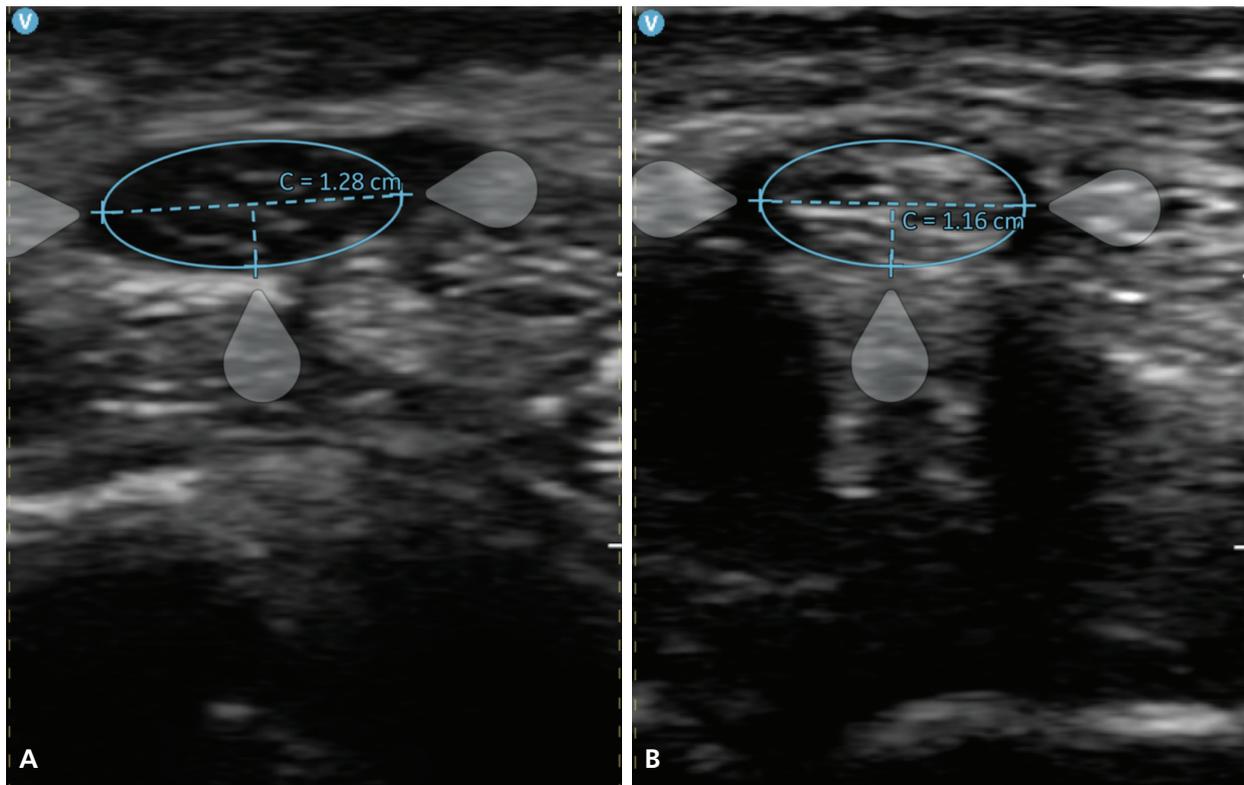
Ultrasound imaging at the carpal tunnel of the right median nerve (A) and the left median nerve (B). Circumference of the right median nerve: 1.28 cm. Circumference of the left median nerve: 1.16 cm.
